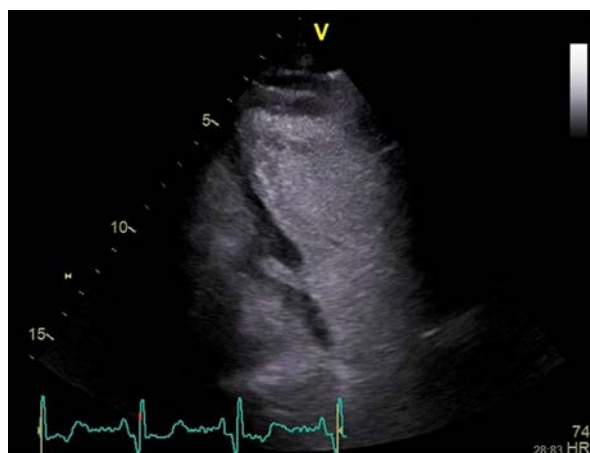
Left ventricle diverticulum in dextrocardiac patient diagnosed using contrast echocardiography.
